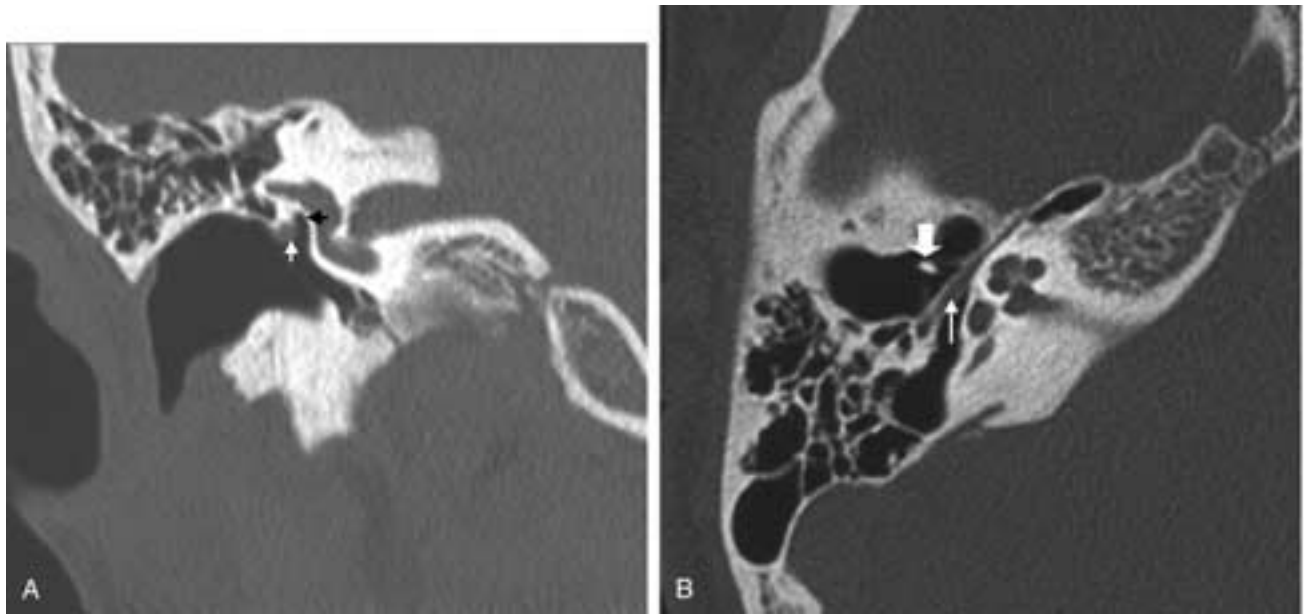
Inferior migration of the facial nerve, absent stapes, and stenotic oval window. A, Coronal CT image showing inferior migration of tympanic segments of the facial nerve (*white arrow*) approaching the stenotic oval window (*black arrow*). The stapes is absent. B, Axial CT image showing a low-lying tympanic segment of the facial nerve (*white arrow*) in the middle ear cavity. Note the handle of the malleus (*white block arrow*) on the tympanic membrane.
